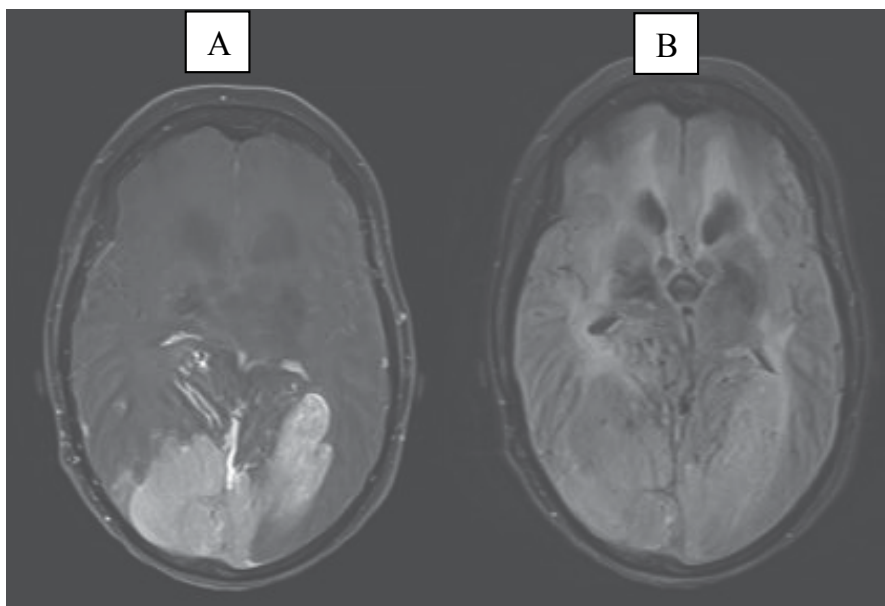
Brain MRI in a patient with multiple malignant meningiomas and brain atrophy. The patient has received cranial radiation for ALL 18 years prior to the initial meningioma diagnosis.
